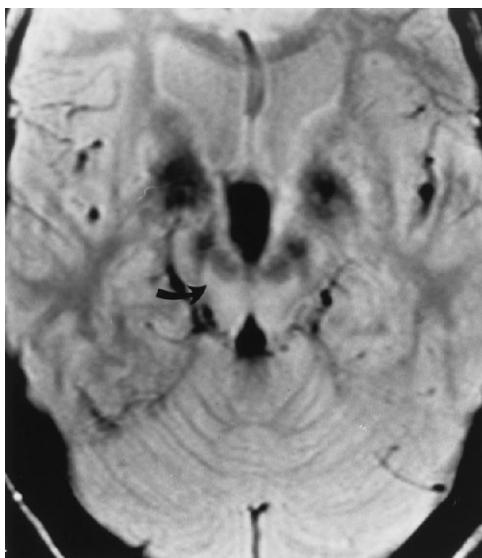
Abnormal dentatorubrothalamic tract (case 10) with high signal intensity around the red nucleus (*arrow*) on a T2-weighted MR image (2000/50).
